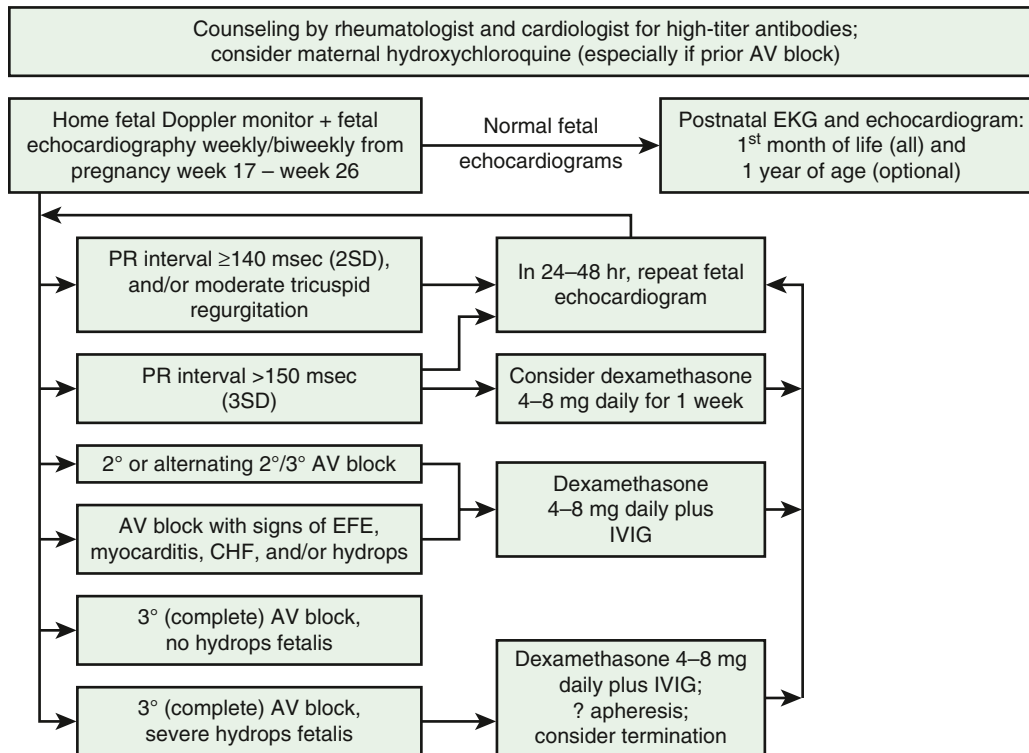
Suggested algorithm for the management of anti-Ro ± anti-La pregnancy. All such pregnancies should include counseling and serial fetal echocardiograms.
